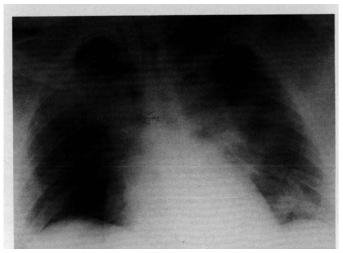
Chest roentgenogram of Patient 5 within 1 hour of his obstructive event, demonstrating diffuse pulmonary edema.
